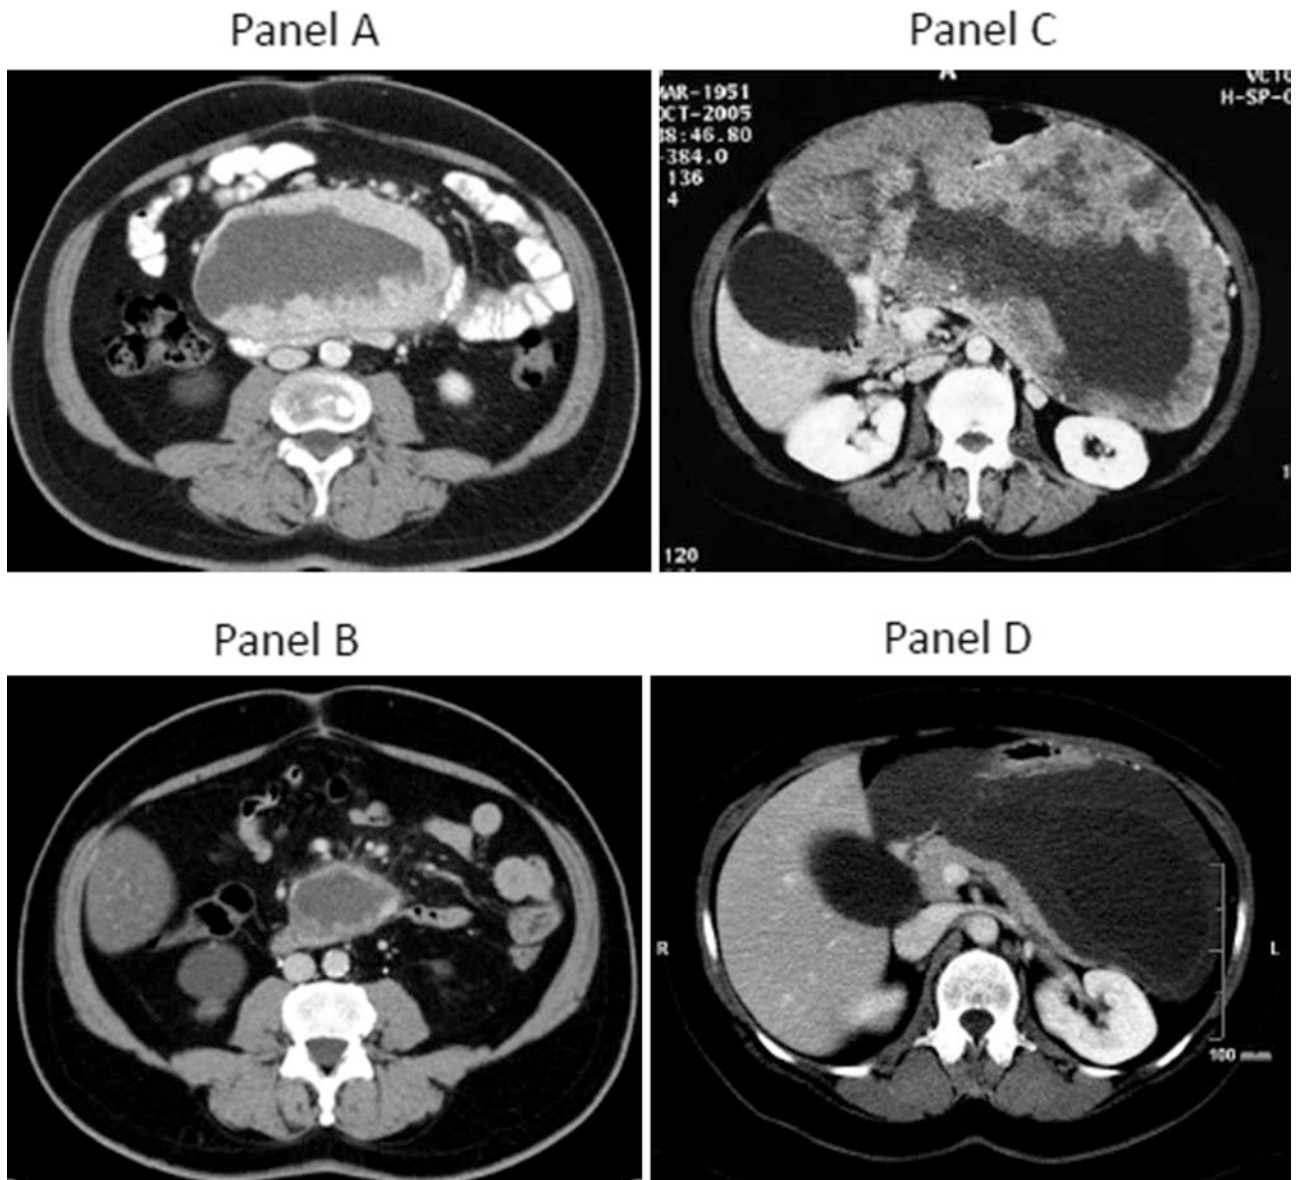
Contrast enhanced CT scan, venous phase, of a primary large duodenal GIST abutting superior mesenteric vessels before (panel a) and after (panel b) 12 months of medical therapy with Imatinib: a major shrinkage has occurred, improving quality of surgical margins. Contrast enhanced CT scan, venous phase, of a primary large necrotic and highly vascularized gastric GIST before
